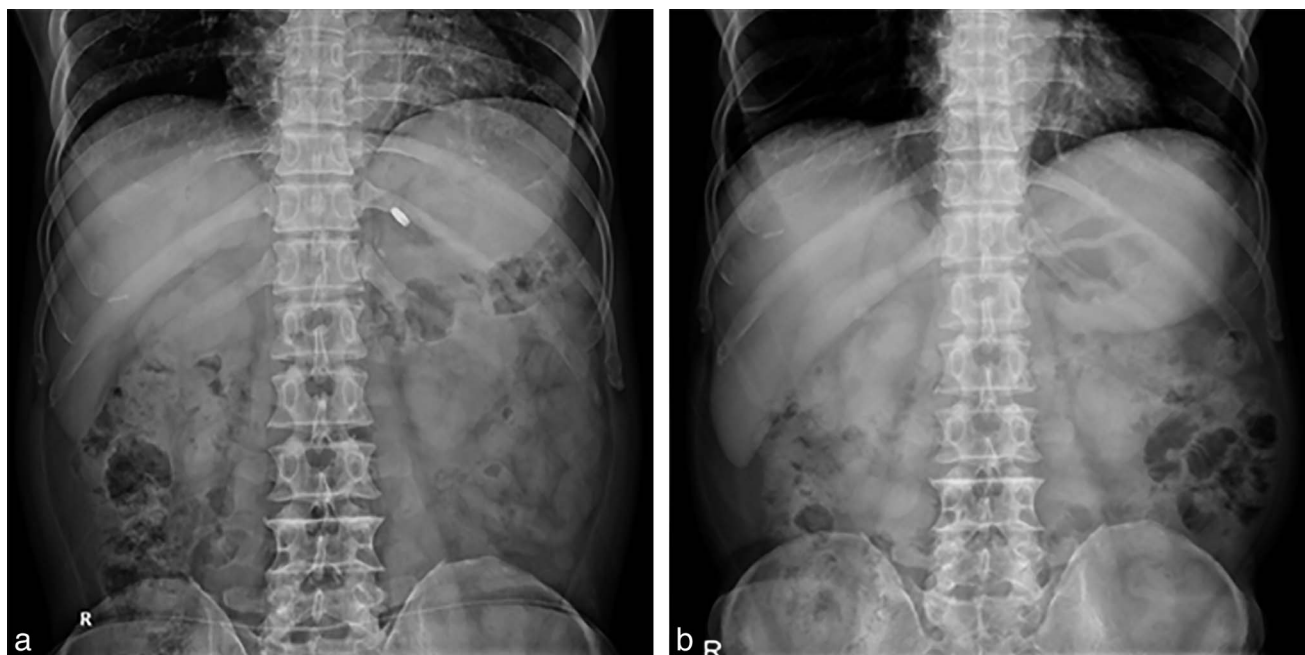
An immediate postoperative radiograph revealed a 1.36×0.6 cm well-defined foreign object in the left upper quadrant (a). However, no foreign body was detected in an abdominal X-ray that was taken 1 year later (b).
